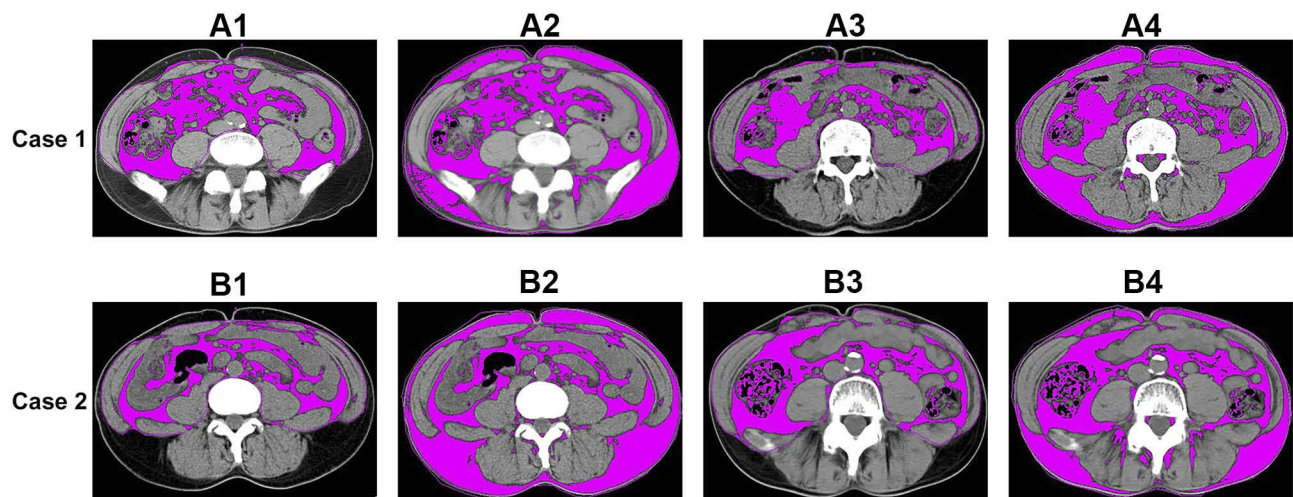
Case 1: Axial CT images of a patient with worse clinical outcomes at the level of the umbilicus. (PFS=4 months; OS=29 months). A1. The region in red represents the VFA at baseline (VFA=194.28 cm²). A2. The region in red represents the TFA at baseline (TFA=203.40 cm²). A3. The region in red represents the VFA at progression (VFA=48.65 cm²). A4. The region in red represents the TFA at progression (TFA=96.82 cm²). Case 2: Axial CT images of a patient with better clinical outcomes at the level of the umbilicus. (PFS=15 months; OS=46 months). B1. The region in red represents the VFA at baseline (VFA=26.34 cm²). B2. The region in red represents the TFA at baseline (TFA=133.00 cm²). B3. The region in red represents the VFA at progression (VFA=72.16 cm²). B4. The region in red represents the TFA at progression (TFA=126.30 cm²).
